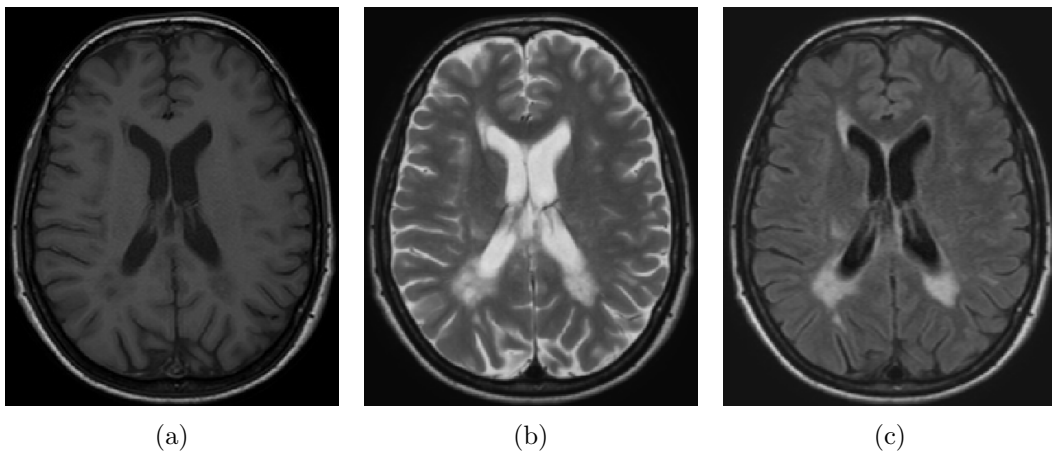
(a) Brain MRI from a MS patient in T1-w modality, (b) Brain MRI from a MS patient in T2-w modality, (c) Brain MRI from a MS patient in T1-w modality. (source: patient18 from Lesjak’s public dataset Lesjak et al. [2016])
